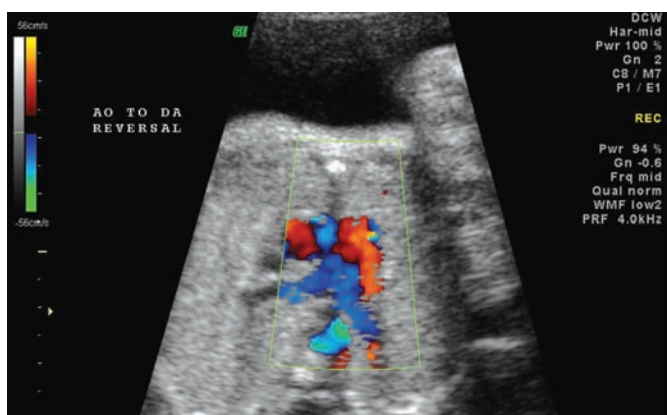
Color Doppler of normal pulmonary artery bifurcation with pulmonary valve atresia and reversed ductus arteriosus flow pattern.
